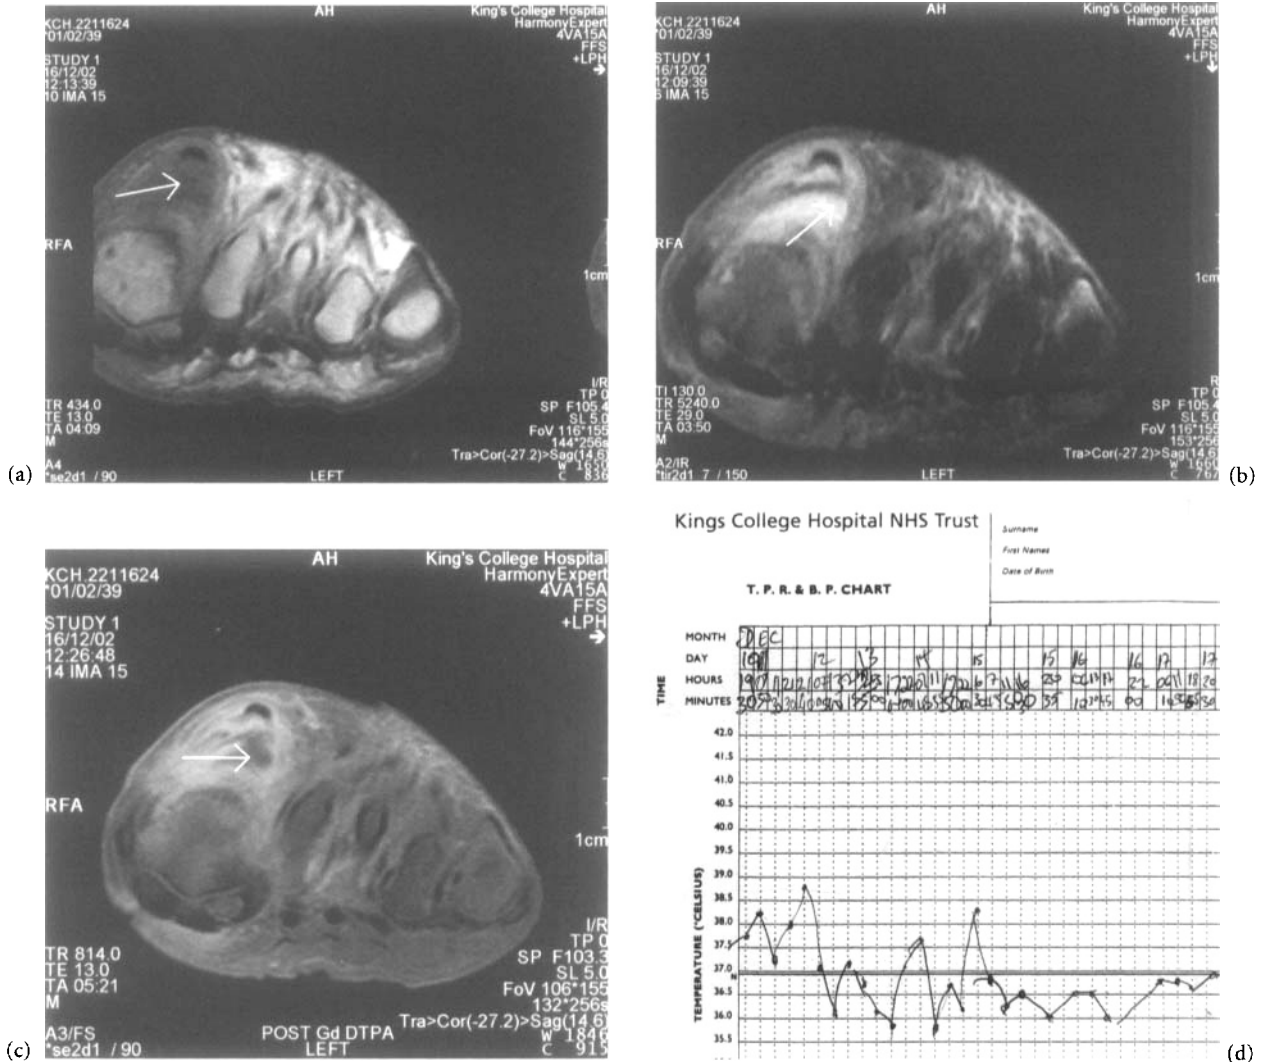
(a) MRI T1 sequence shows normal uptake in soft tissues under extensor hallucis longus tendon. (b) Increased uptake on STIR sequence. (c) A small collection of fluid under
